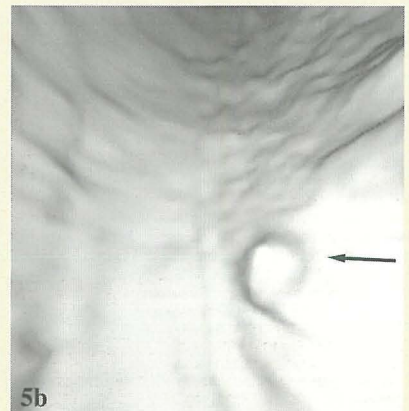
(a) Axial CT scan shows a small polyp (arrow) in the sigmoid colon. (b) Three dimensional endoluminal view shows the same polyp (arrow).
